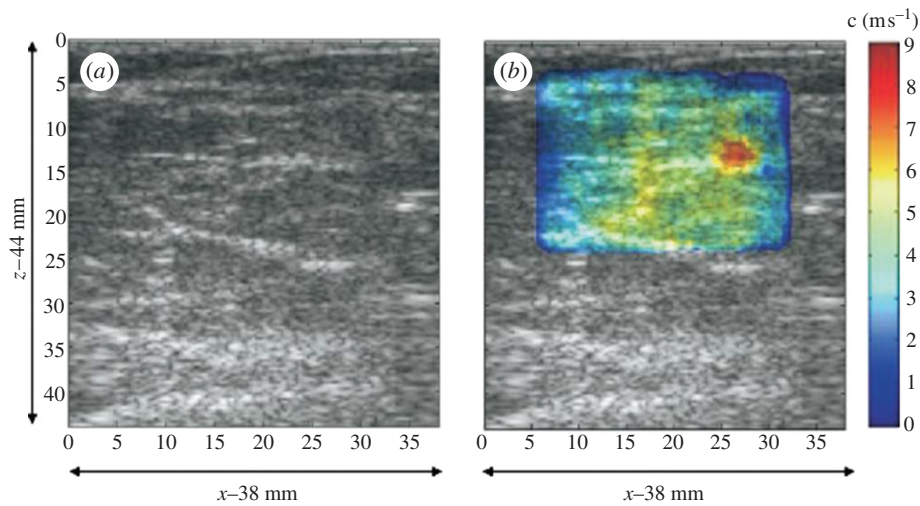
Characterization of a 5 mm grade III infiltrating ductal carcinoma using SuperSonic Imaging and an L74 linear imaging array (centre frequency 5 MHz). The B-mode image (a) shows a slightly hypoechoic region that is clearly delineated as stiff (red) in the corresponding shear wave velocimetry map (b). (Reproduced with permission from *Ultrasound in Medicine and Biology* [60]).
